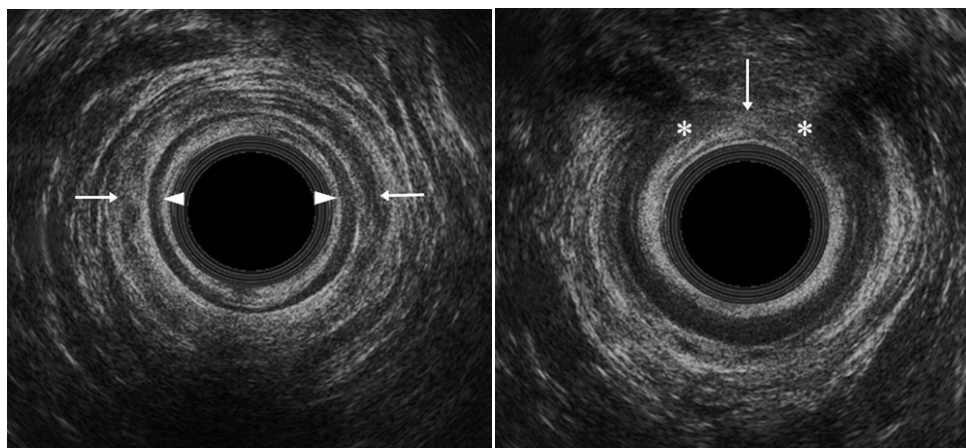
Transverse endo-anal ultrasound image at level of mid anal canal shows anterior defect of internal anal sphincter muscle (arrow). Astericks shows the edges of internal sphincter muscle (AJR June 2010)
